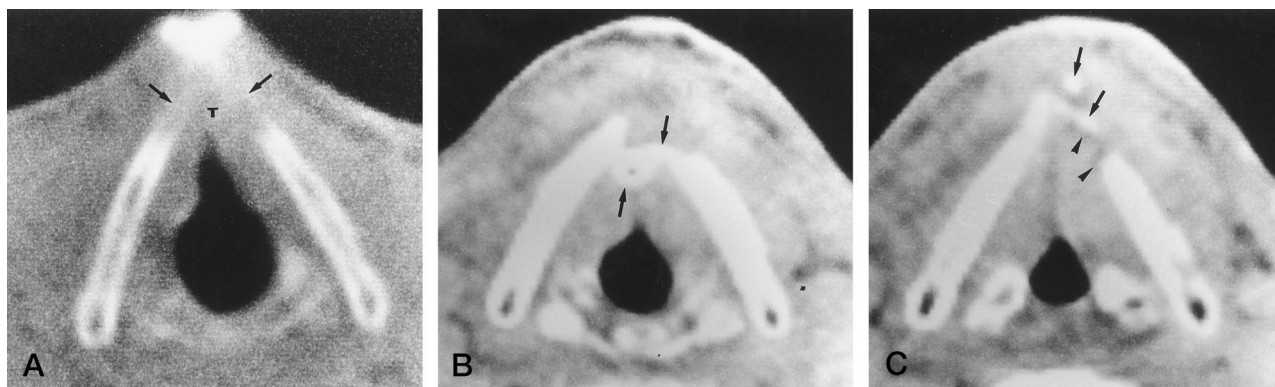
A, Pretreatment CT scan of a patient with a T2 glottic carcinoma shows tumor (T) most likely invading the cartilage at the anterior commissure (arrows).
